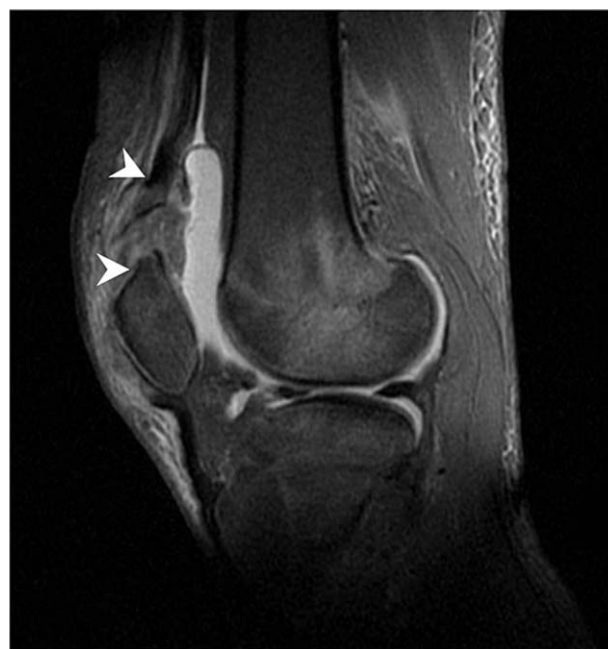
Quadriceps tendon rupture, cartilaginous injury (arrowheads), and joint effusion are visualized at 1.5 T magnetic resonance image (sagittal view, FSE sequence, TR 3,700ms, TE 46ms).
